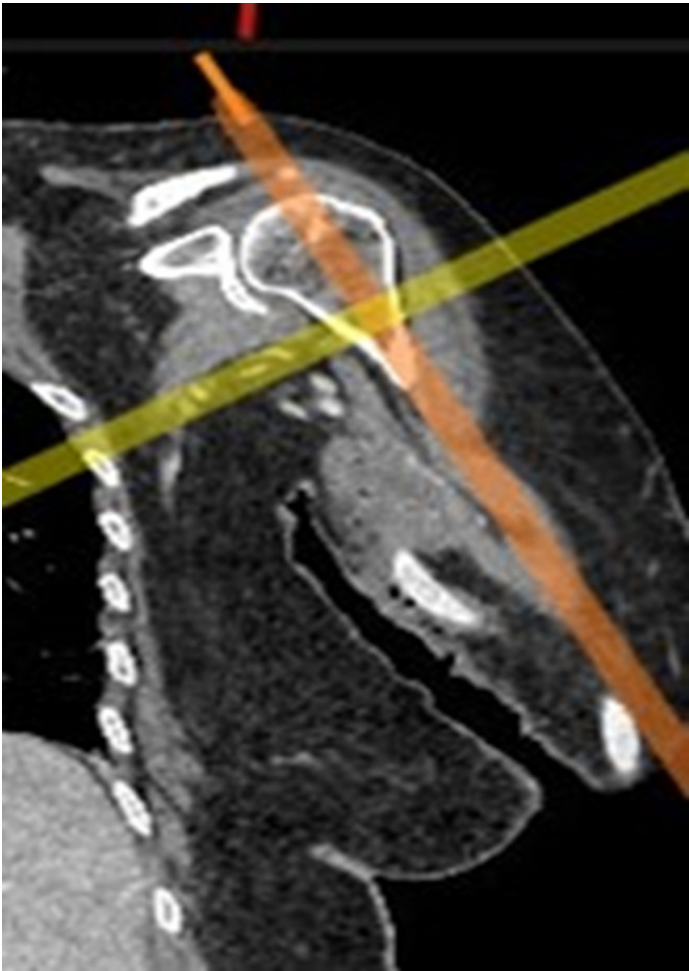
Representative CT image demonstrating alignment of the surgical neck (collum chirurgicum) to the orthogonal plane [intersection point of the vertical axis (orange line) and the transverse axis (yellow line) in the frontal plane]
